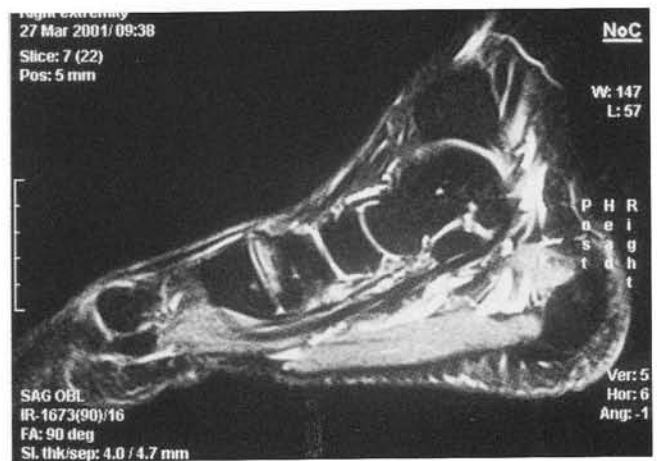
Lateral T2-weighted image of os tibiale externum.
